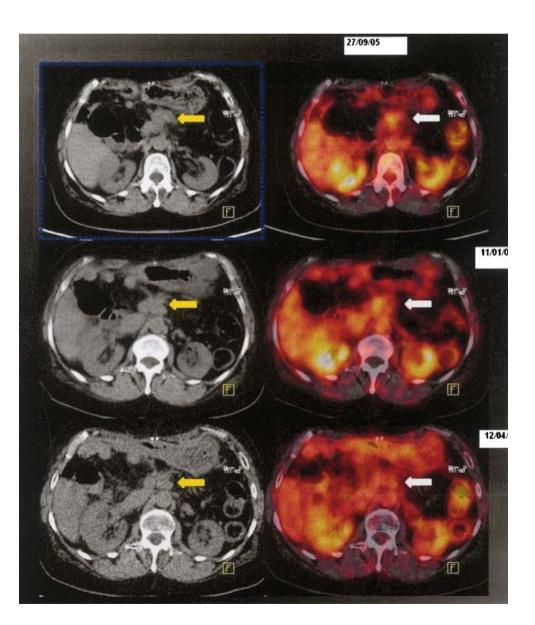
Top to bottom Tumor relapse (white arrows) 39 months after a PPPD detected by FDG-PET, while CT (yellow arrows) was unchanged with respect to previous examinations. Three months later, after completing chemoradiotherapy, CT was unchanged but FDG-PET was still positive (with decreased SUV). Stereotactic radiotherapy was performed and FDG-PET was negative 3 months later. The patient died of disseminated disease 15 months later (5 years after PPPD).
